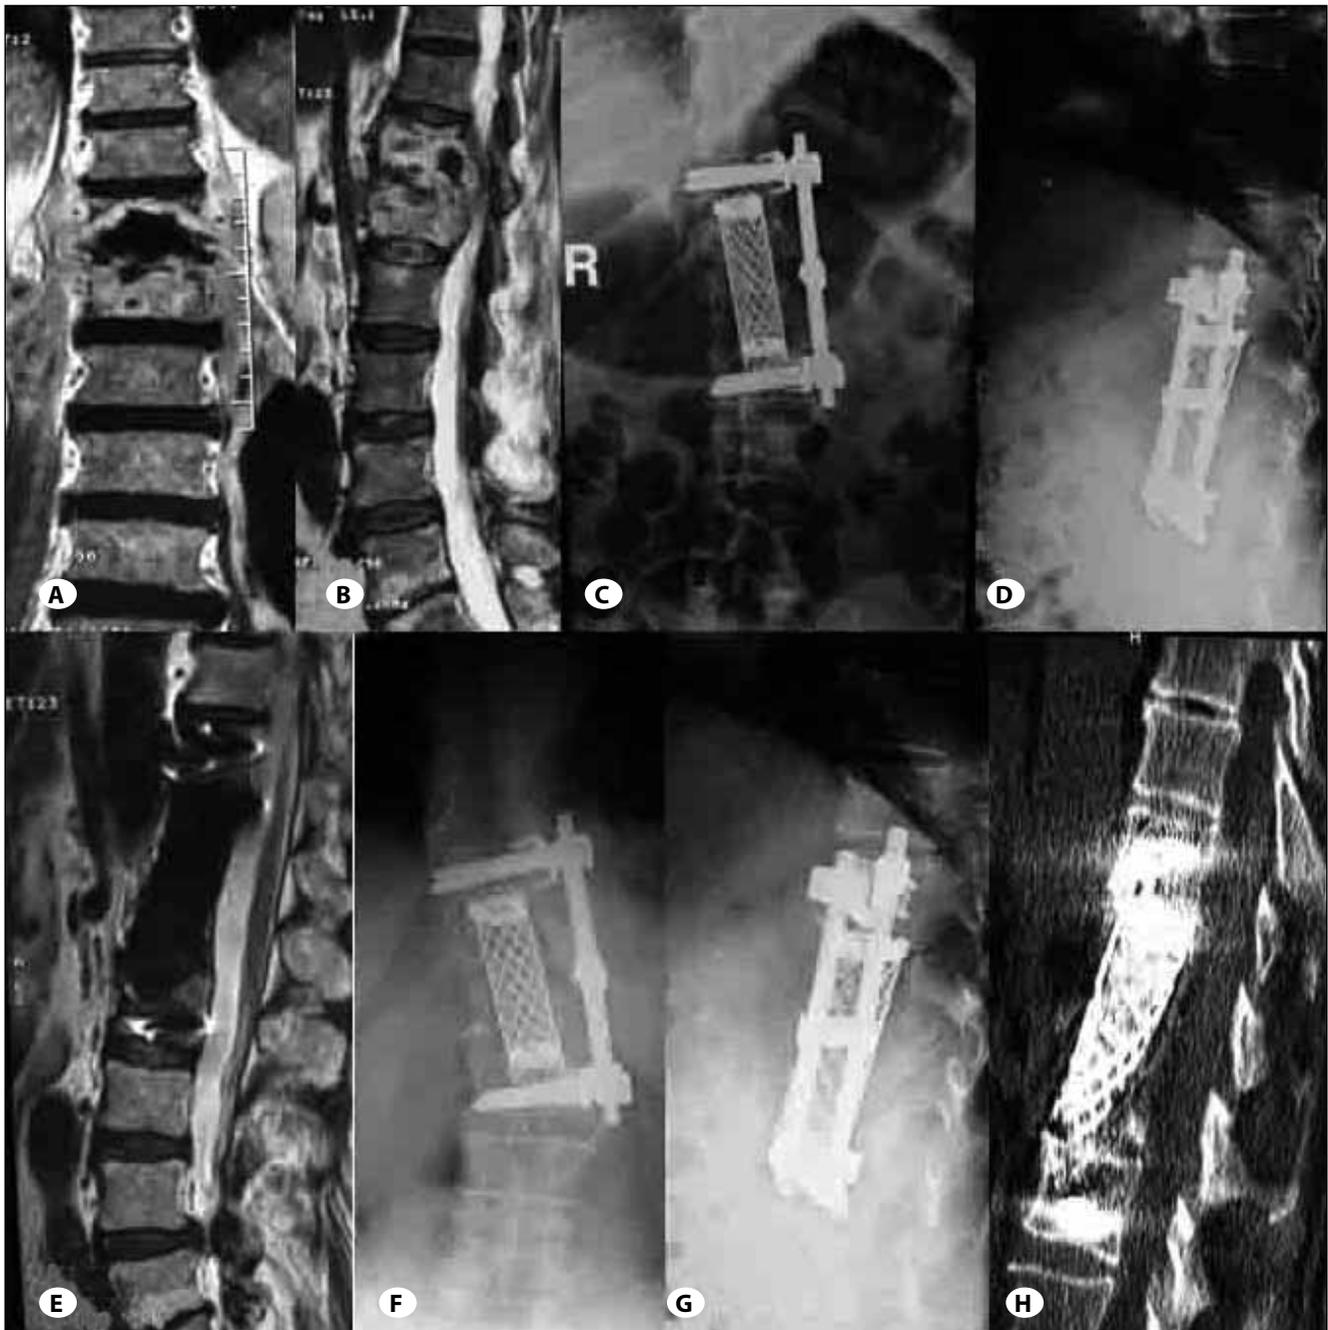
63 year-old male with T12/L1 spinal tuberculosis and mild osteoporosis. A) and B) Preoperative MRI revealed destruction of the T12 and L1 vertebra, a large left psoas abscess and epidural abscess causing compression of spinal cord. C) and D) Immediate postoperative radiographs demonstrating anterior radical debridement, placement of a titanium mesh cage T11-L2 and dual-rod anterior instrumentation. E) Immediate postoperative MRI revealed adequate decompression of the spinal cord. F) and G) Plain radiographs at 6 years revealed subsidence of the cage 3mm into the cephalad endplate and 13mm into the caudal endplate with a decrease of intervertebral height of 16mm and an increase in kyphotic angle of 6°. The scoliosis was measured at 16°. H) Sagittal CT reconstruction demonstrated a solid fusion around the cage.
